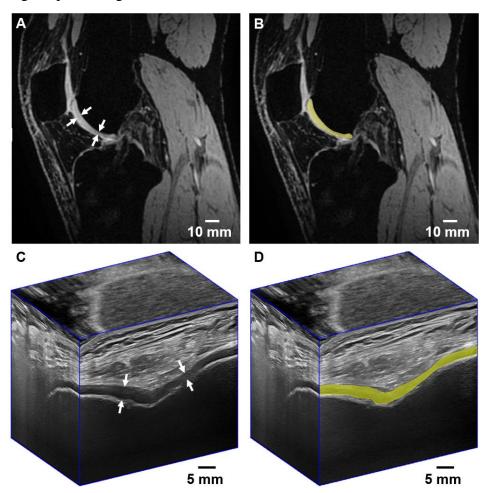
MERGE MRI (A) and 3D US (C) images of the trochlear articular knee cartilage outlined by the white arrows in the sagittal MRI and transverse US planes of a healthy volunteer, accompanied by the same images with an overlaid MRI (B) and 3D US (D) slice that has been manually segmented.
